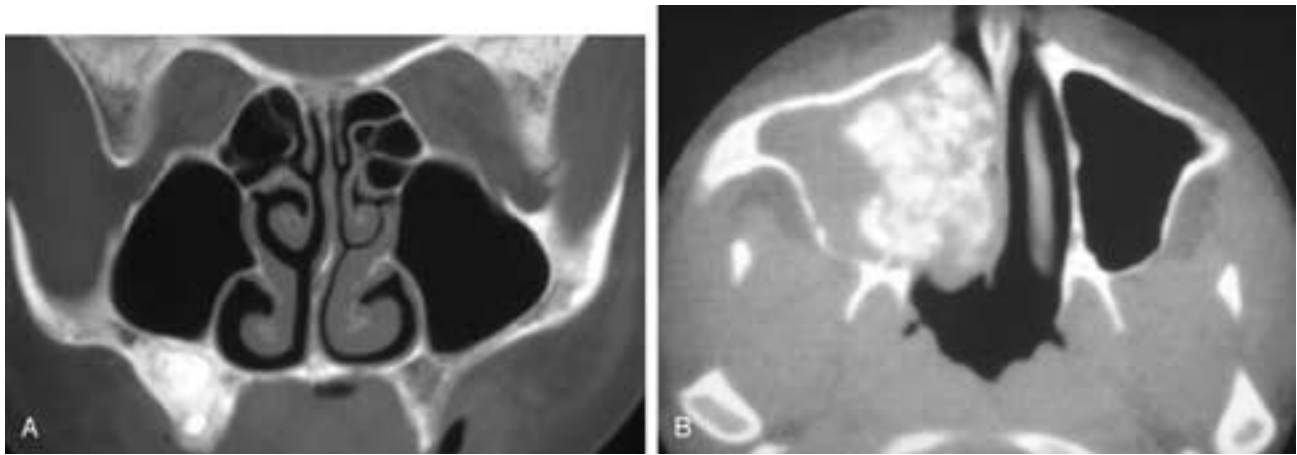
Coronal CT scan (A) shows a very dense nodular mass in the right maxillary alveolus. Axial CT scan (B) on another patient shows a mass in the right maxillary sinus with numerous discrete radiodensities. Obstructed secretions are present laterally in the sinus. Both of these patients had a complex odontoma.
